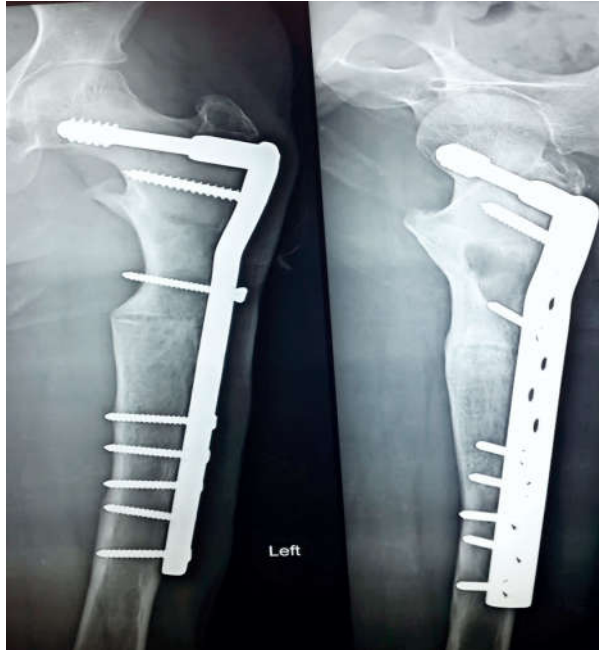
Post operative radiograph at 14 months follow up
